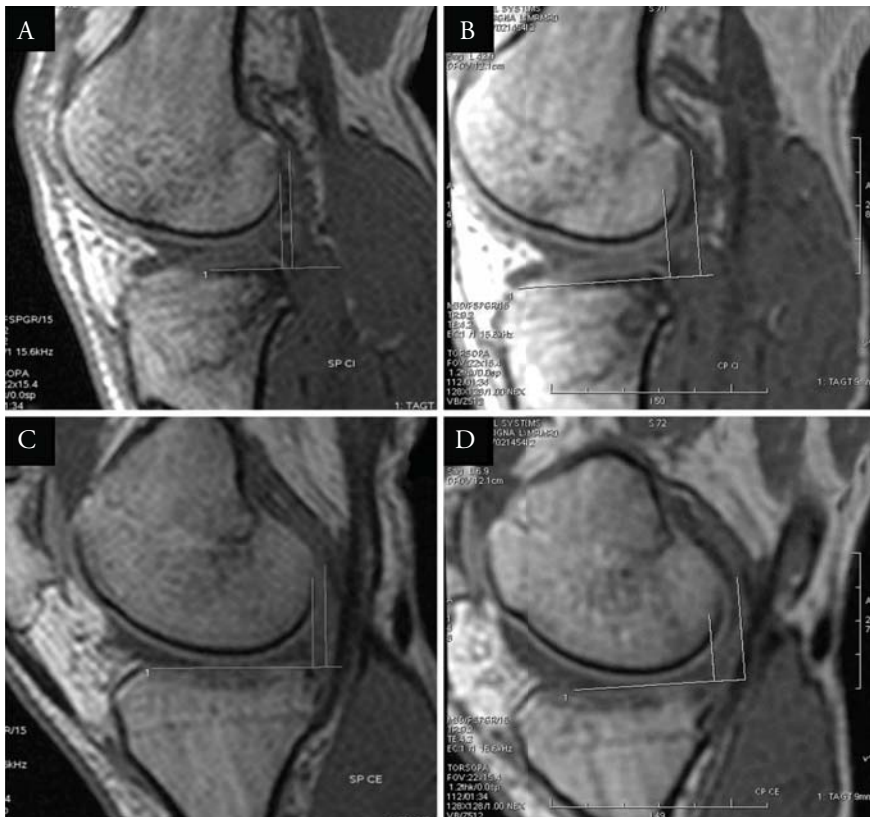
MRI images of injured knee obtained using the PKTD: medial compartment without (A) and with pressure (B); and lateral compartment without (C) and with pressure (D).
